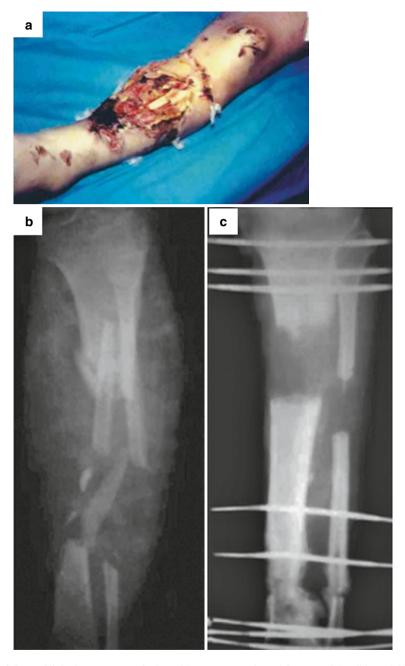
(a) Clinical appearance of a leg with open contaminated fracture of the tibia and fibula. (b) X-ray showing segmented fracture with bone loss and comminution. (c) After repeat debridement and external fixation with FED, the gap was 13 cm. (d) After corticotomy and lengthening were performed. (e) After plastic skin coverage. (f) Consolidation of the bone at 6 months. (g) Consolidation of the bone at 1 year
